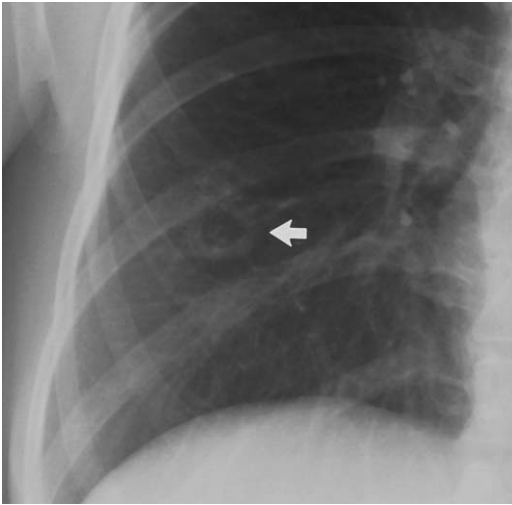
Targeted view of a chest radiograph shows a cavity in the right lower lung (*arrow*). Although the walls of the cavity are thick, the internal contours of the cavity are smooth. This cavity was caused by histoplasmosis.
